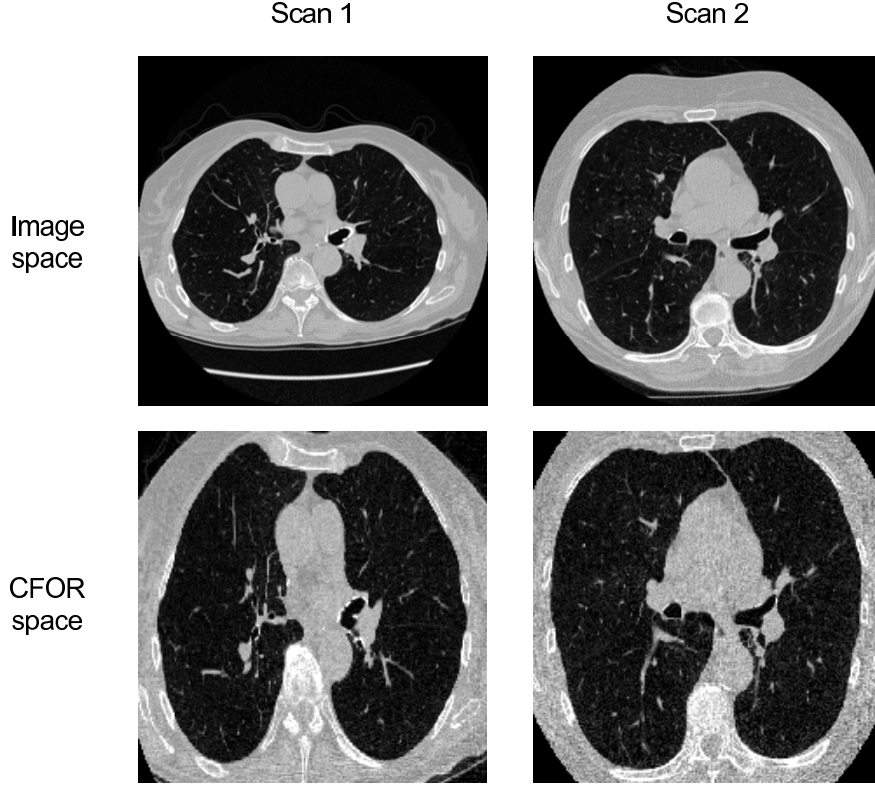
Examples of CFOR mapping. Two scans of different patients are mapped to the CFOR space. The CFOR normalizes for different individuals based on their rib size and position within CT images.
